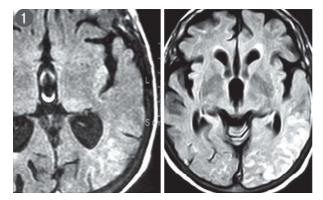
Oranial MRI: FLAIR sequence showing hyperintensity in the left parieto-occipital region. In the picture on the left, it is possible to see how the lesion shows enhancement after contrast.
